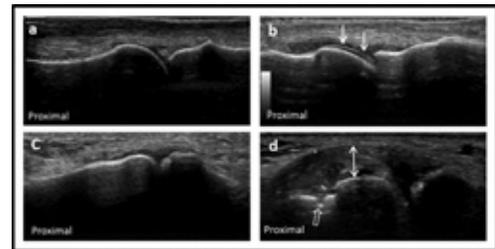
Ultrasound Features in Patients with Hyperuricaemia. Dorsal longitudinal ultrasound of MTP1 in (a) isolated hyperuricaemia, (b) hyperuricaemia with non-specific foot pain. The presence of Double Contour sign due to articular cartilage MSU deposition is shown in (b) (solid arrows). (c) Medial longitudinal ultrasound of MTP1 in (c) isolated hyperuricaemia and (d) hyperuricaemia with non-specific foot pain. The presence of tophus (double headed arrow) and juxta-articular erosion (open arrow) over the medial surface of the 1<sup>st</sup> Metatarsal in (d) is shown. (Greyscale images obtained using LogiqG9 at 15MHz).
